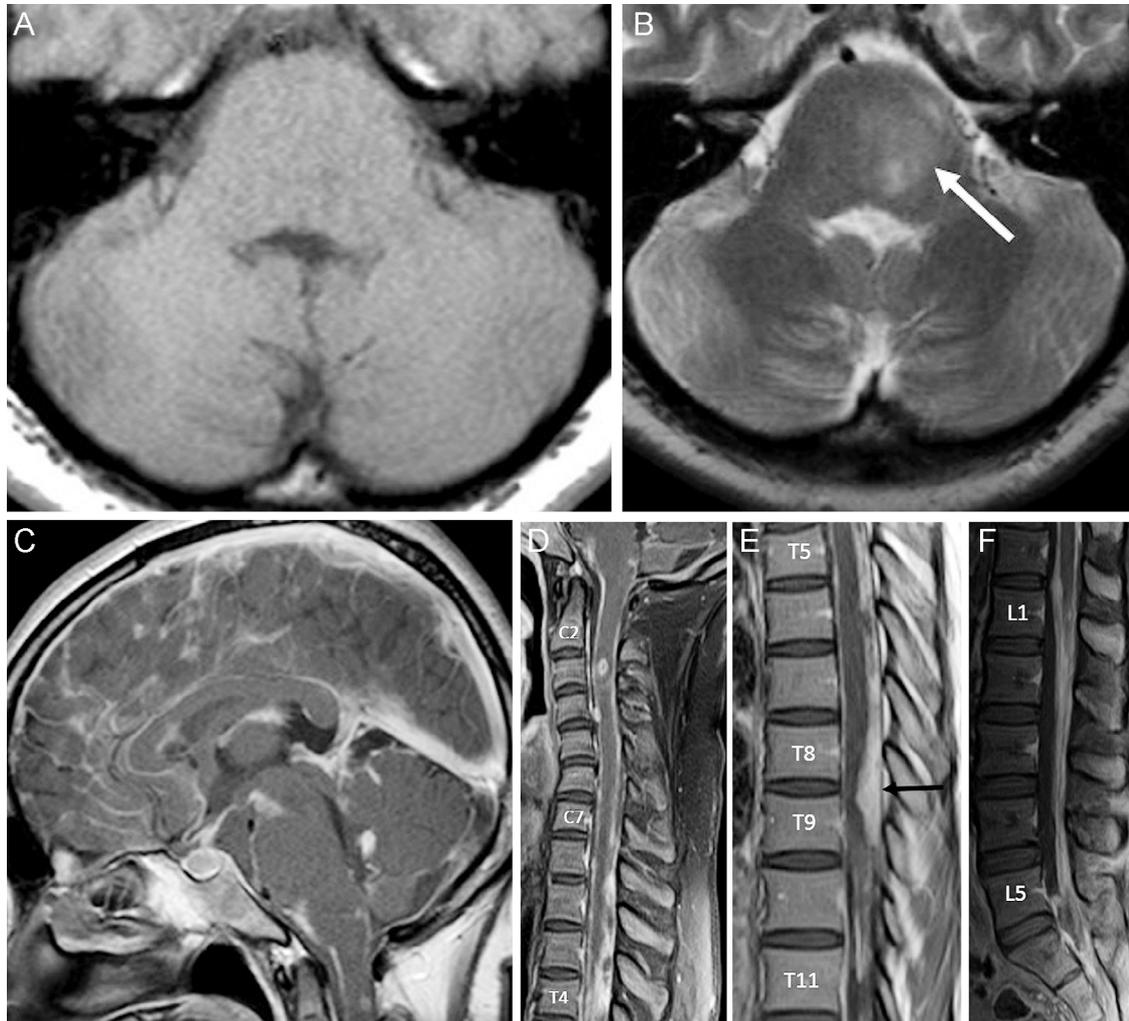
Axial T1- (A) and T2-weighted images, (B) postcontrast sagittal T1-weighted image of the brain (C), and postcontrast sagittal T1-weighted images of the spine (D-F) after 2 months showing extensive leptomeningeal dissemination and enlargement of the pons (A arrow). Spinal dissemination is thickest between the T8 and T9 levels (D arrow).
